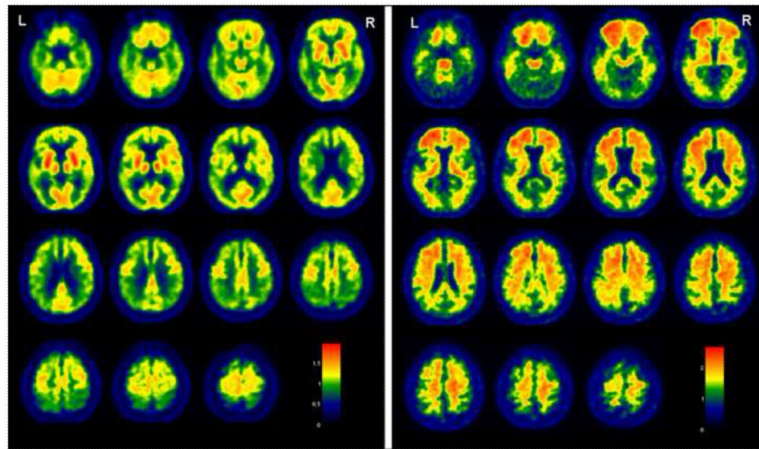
Representative slices from PiB-PET and FDG-PET images
